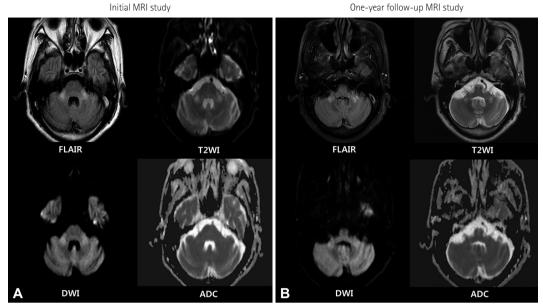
A case of neurosyphilis with prolonged bilateral MCP hyperintensity. A: FLAIR and T2WI showed a hyperintense lesion bilaterally in the MCP. DWI revealed the hyperintensity, but ADC mapping displayed no alteration in the same lesion. B: These MRI findings were sustained at the 1-year follow-up. ADC: apparent diffusion coefficient, DWI: diffusion-weighted imaging, FLAIR: fluid-attenuated inversion recovery, MCP: middle cerebellar peduncle, MRI: magnetic resonance imaging, T2WI: T2-weighted images.
